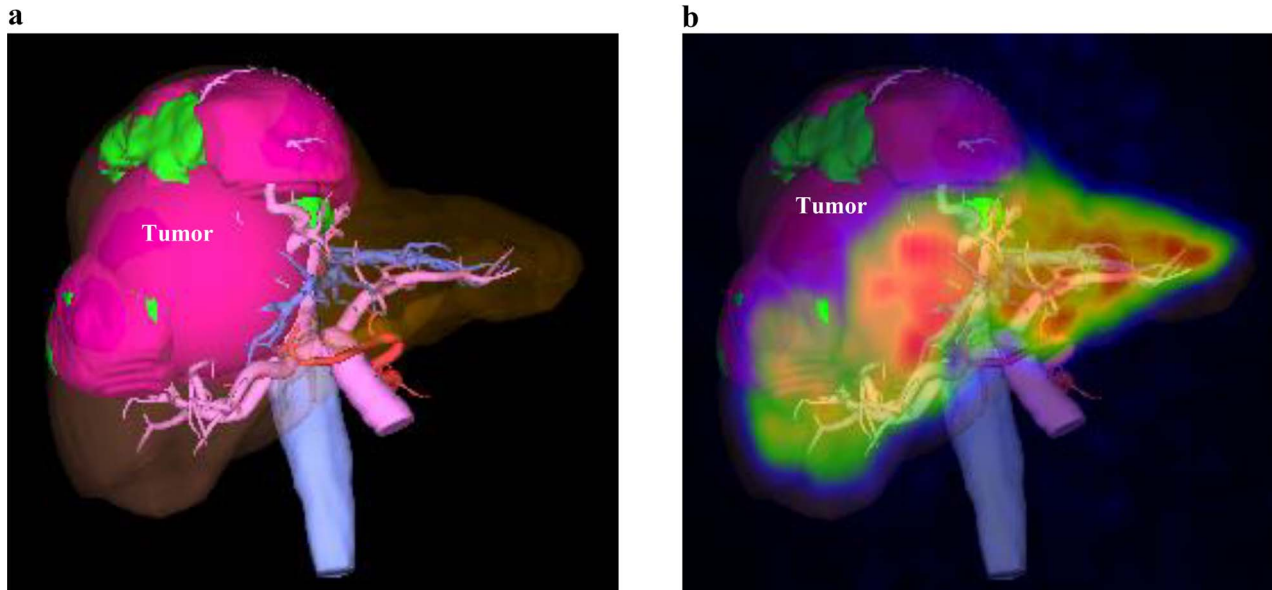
Creation of a 3D-CT/ ^{99m}Tc -GSA SPECT fusion image using the volume analyzer Synapse Vincent. (a) Evaluation using the 3D image. (b) Evaluation using the SPECT/CT fusion image. CT, computed tomography; SPECT, single-photon emission computed tomography; ^{99m}Tc -GSA, technetium-99m-diethylenetriamine-pentaacetic acid galactosyl human serum albumin.
